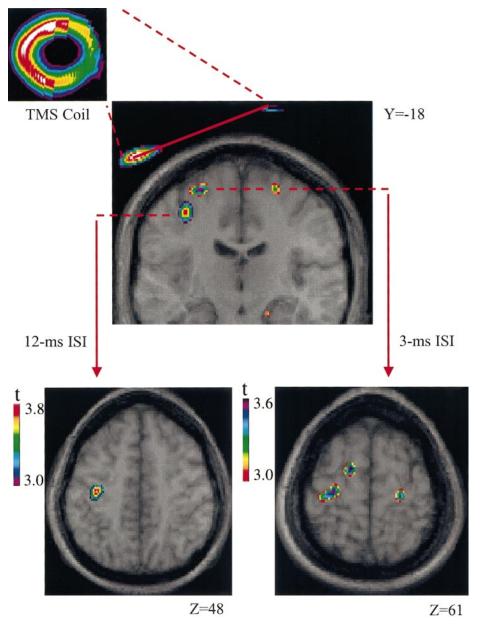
The *top* of the figure shows the position of the TMS coil obtained with the transmission scan to verify the coil position relative to subject's head. The superimposed coronal section of merged positron emission tomography/magnetic resonance imaging (PET/MRI) volumes show the locations of brain regions in which cerebral blood-flow (CBF) differences co-varied significantly with the amount of EMG suppression and facilitation. The *bottom figures* show horizontal sections of 12-ms (*left*) and 3-ms (*right*) paired-pulse TMS scans.
